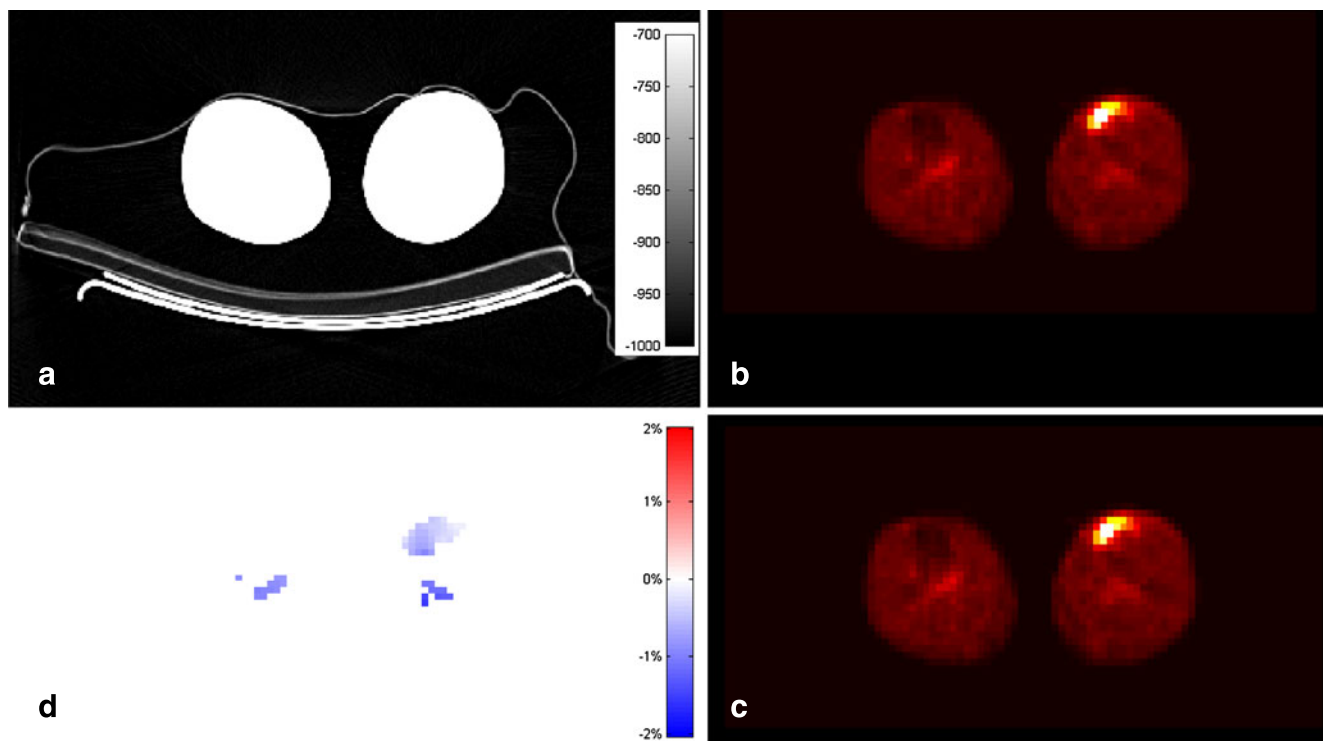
[^{18}F]FDG imaging of a patient with a lesion of the lower extremities, axial images: (a) CT (in HU) with foam support of extremities, covered by thin blanket, (b) PET following origCT-AC, (c) PET following modCT-AC, (d) difference (percent, $\pm 2\%$ max) image of b and c
